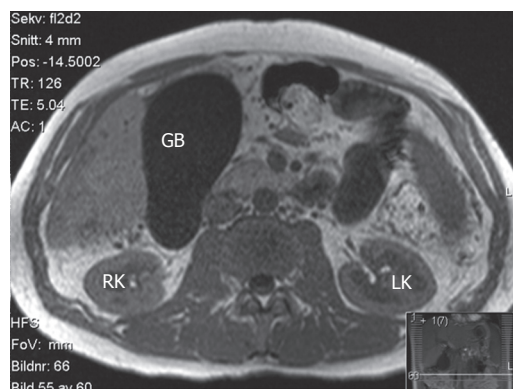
MRI showing a large gallbladder volume of 348 mL in a patient with PSC.
